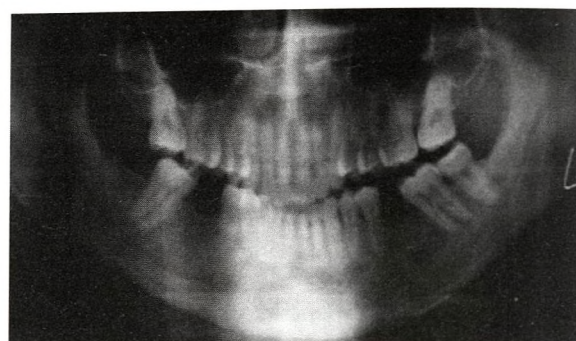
Intermediate - dental panoramic radiograph showing reduction of the right lateral and vertical extensions of the radiolucent lesion.
